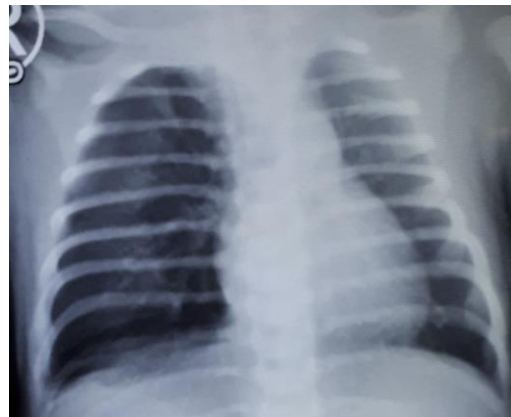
the chest X-Ray evaluation of Baby H showed no pneumothorax
